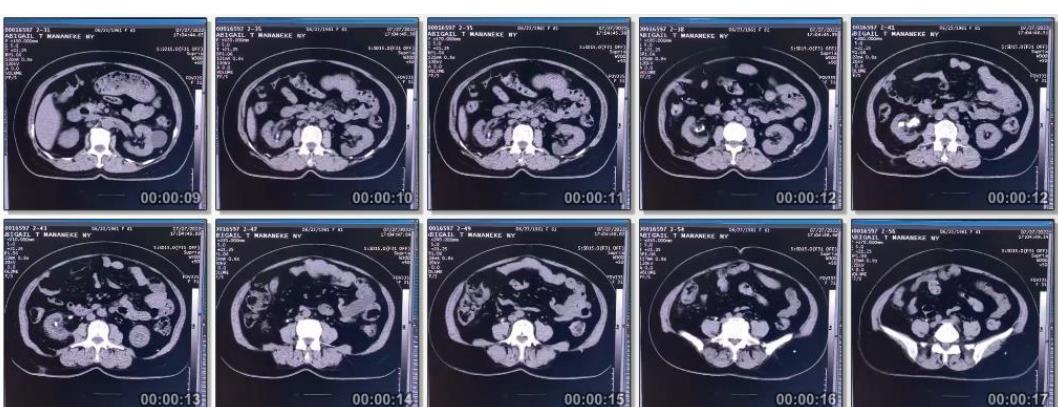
CT-scan axial view
